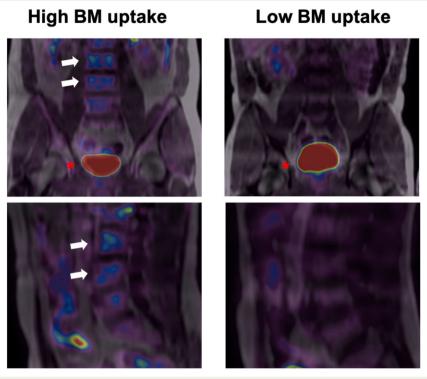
Bone marrow uptake. Representative baseline ¹⁸F-fluorodeoxyglucose positron emission tomography/magnetic resonance imaging scans from participants. The left panel shows fused ¹⁸F-fluorodeoxyglucose positron emission tomography/magnetic resonance imaging in coronal (upper) and sagittal (lower) views. L3 and L4 vertebrae (white arrows) present high ¹⁸F-fluorodeoxyglucose uptake (visualized in blue). The right panel shows the same coronal and sagittal views; ¹⁸F-fluorodeoxyglucose uptake is not visualized. The bladder is visualized in red in both upper panels (red asterisk).
